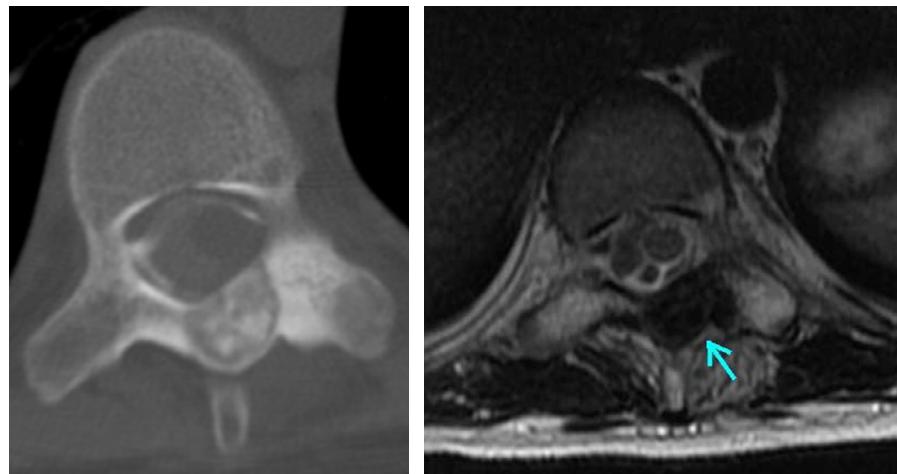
CT revealed a mass lesion in the lamina of the 10th thoracic vertebra. The lesion had a visible nidus (arrow).
